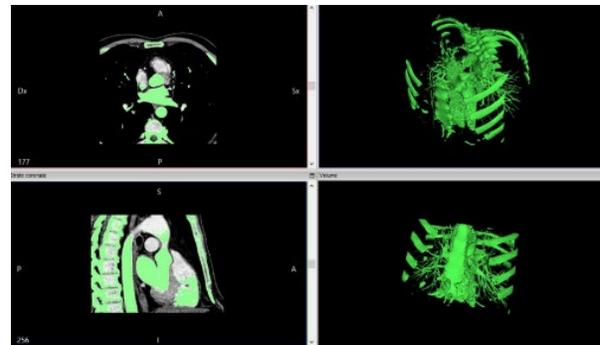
DICOM Image (left) CT scan Procedure and 3D mesh gathering (Right)
